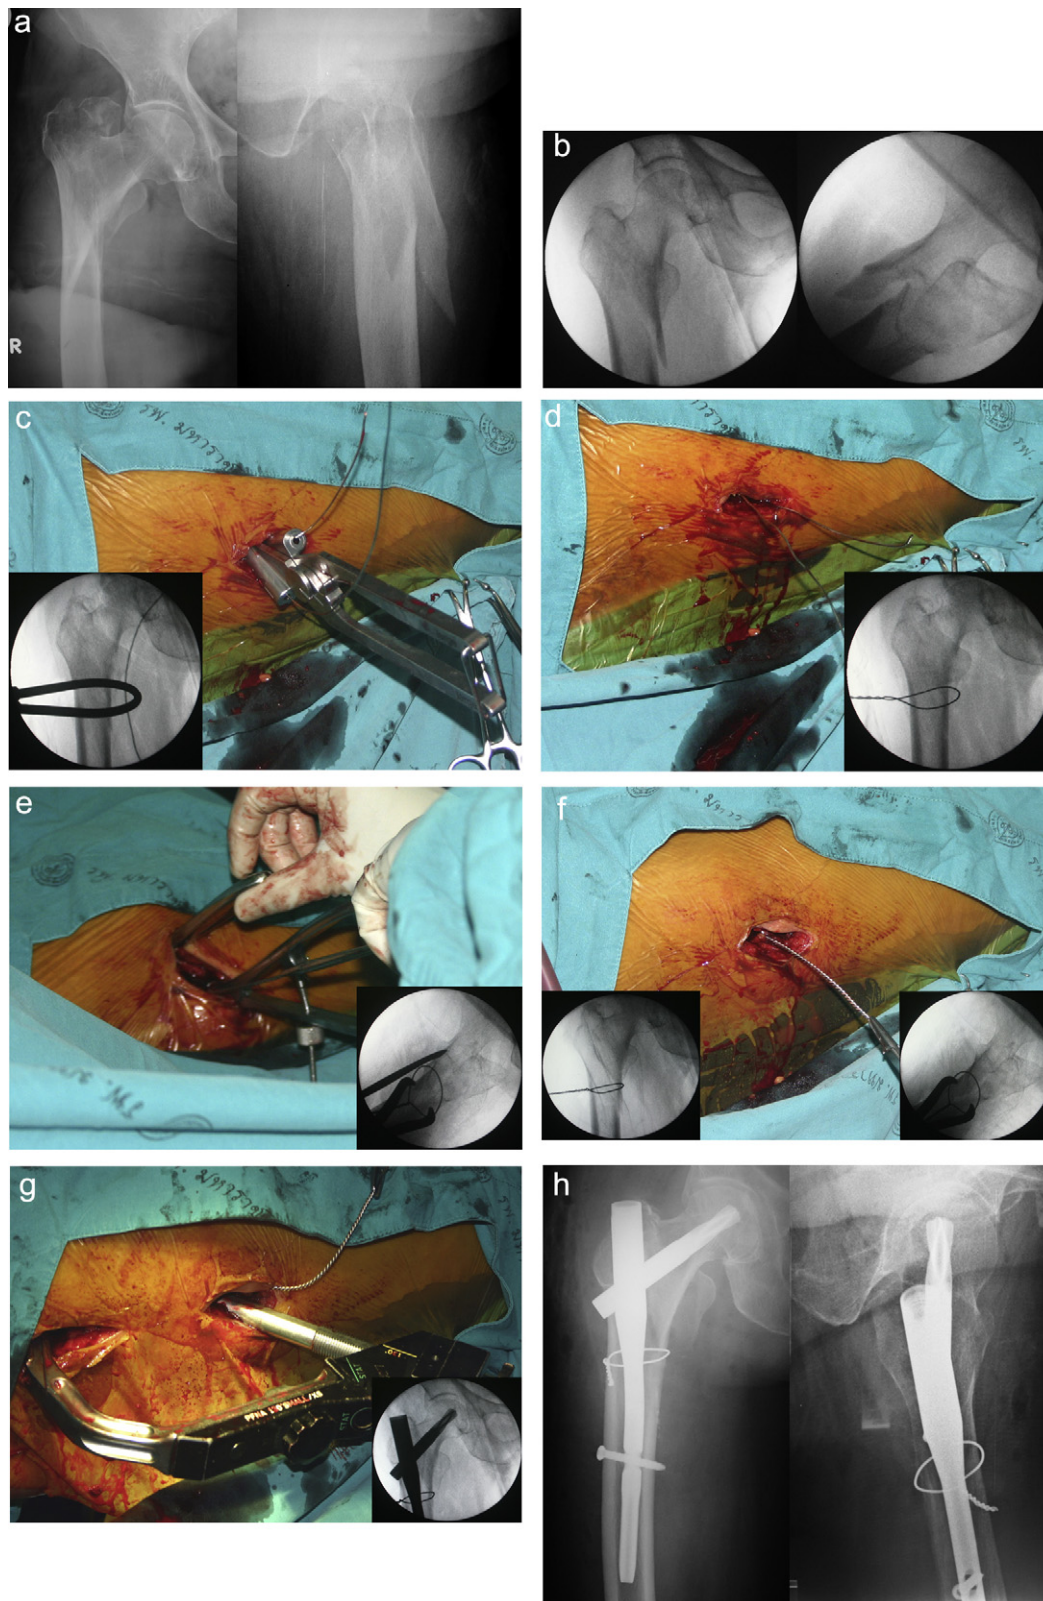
(a) The X-rays of an 81-year-old woman with unstable intertrochanteric fracture. (b) Intraoperative X-rays demonstrated the displacement of the fracture. (c) The cerclage passer was inserted through a three cm incision at the central part of the fracture. (d) A wire loop passed around the fracture. (e) A periosteal elevator and reduction forceps were used to manipulate the fracture. (f) Complete reduction of the fracture by a single wire loop. (g) The fracture was stabilized with a proximal femoral nail using standard technique. (h) The postoperative X-rays showing the fracture fixation with good positioning of the implant.
